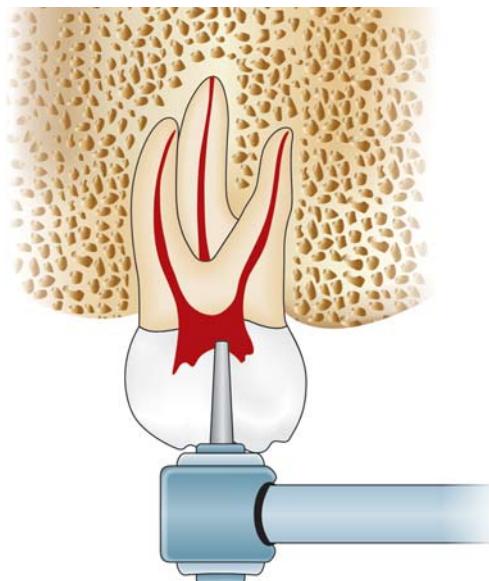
Preoperative radiograph can help to note the position and depth of pulp chamber
